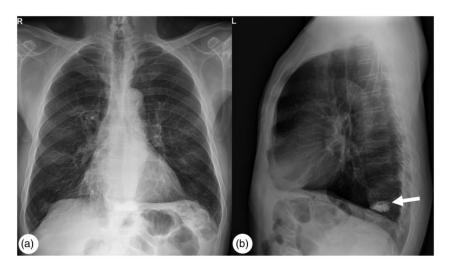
(a) Posteroanterior and (b) lateral chest radiographs on admission showed no active lung parenchymal lesions or bone cement deposition in the TII vertebral body (arrow).
